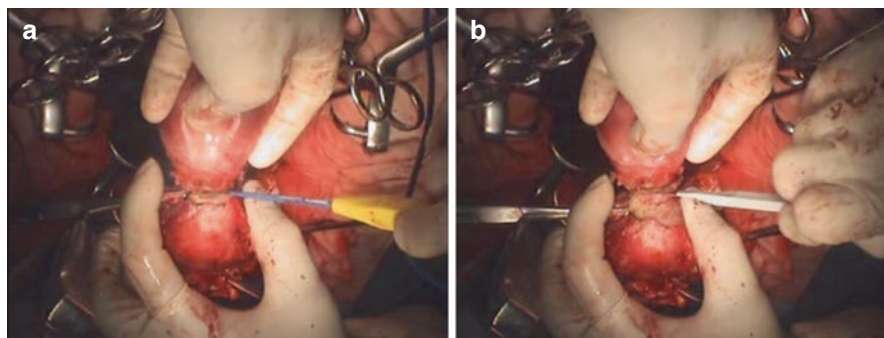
Determination of cervical cutting level by intraoperative ultrasonography. To the serosal surface of the uterine anterior wall, apply an ultrasonic probe (a) and confirm the position of the endocervical canal (b); the incision marking is drawn so that the cervical canal remains at least 5 mm, with 10 mm producing better results, from the endocervix to the vaginal side (c)
